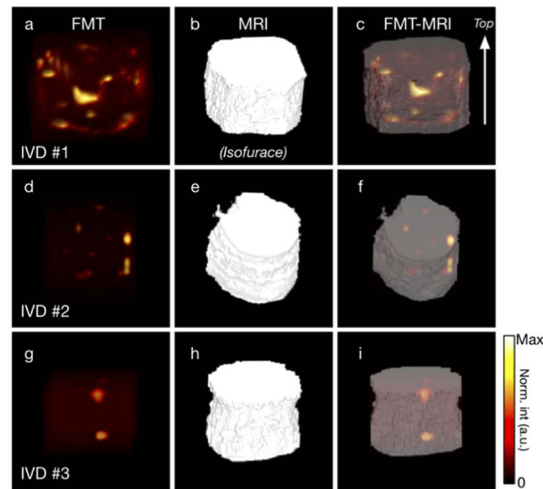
The left column shows 3D MIP visualization of the volumetric FMT data (a,d,g). The middle column shows the segmented iso-surface of the MRI data (b,e,h). Both FMT and MRI images were registered and overlaid in 3D (c,f,i).
